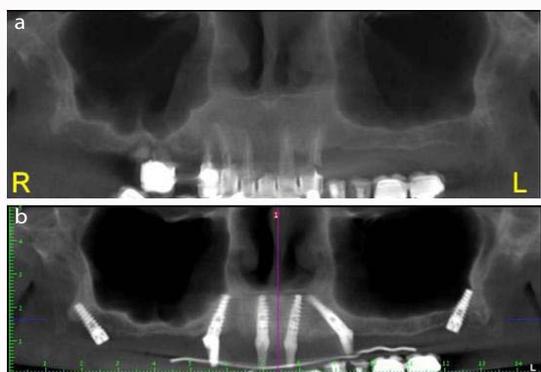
(a) Very extensive maxillary sinus, bilateral. The sinuses occupy the entire body of the maxillae and extend anteromedially to the premaxilla, posterolaterally into the infratemporal regions and superolaterally into the zygomatic process of maxilla. The residual height of the alveolar ridges is 4 mm or less. (b) Postoperative CBCT scan showing bilateral pterygoid implants. The four conventional implants in the premaxilla were immediately loaded and the patient was provided with temporary acrylic bridge with shortened span.
